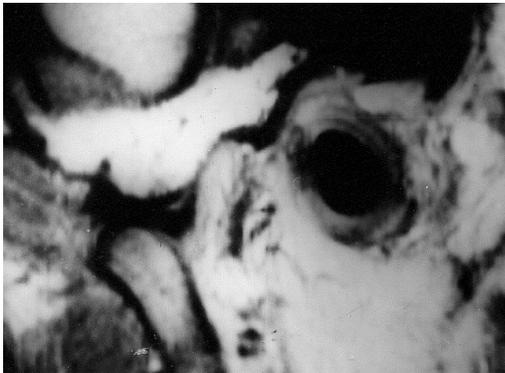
Sagittal MRI of a joint in the open position revealing anterior disc displacement with disc damage.
